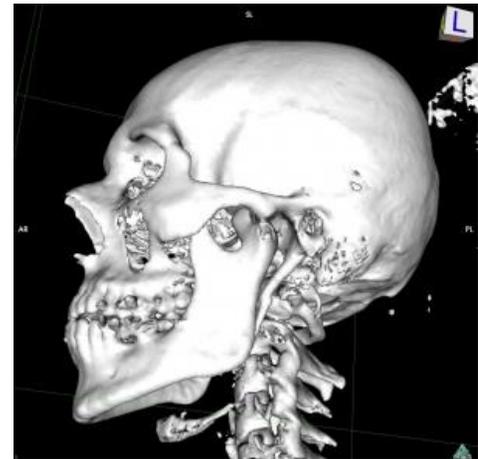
CT scan shows a large bonelike mass at the medial pole of the left temporomandibular condyle.
